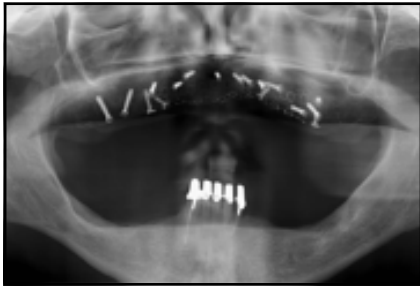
(left) Preoperative panoramic radiograph showing the maxilla augmented with autogenous bone graft from the iliac crest and the minimal bone available superior to the inferior alveolar canal.
